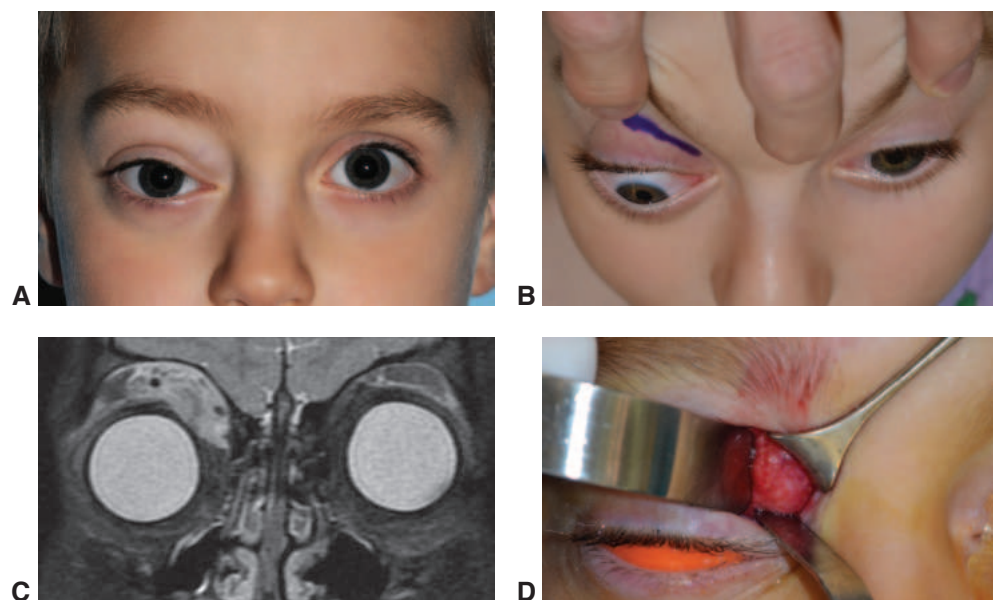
Orbital rhabdomyosarcoma. Lesion presenting as a right upper eyelid mass causing inferolateral globe displacement (A) and proptosis (B). C, T2-weighted MRI shows a mass in the right superonasal quadrant. D, Anterior orbitotomy through the upper eyelid provided tissue for pathologic analysis. (Courtesy of Bobby S. Korn, MD, PhD.)
